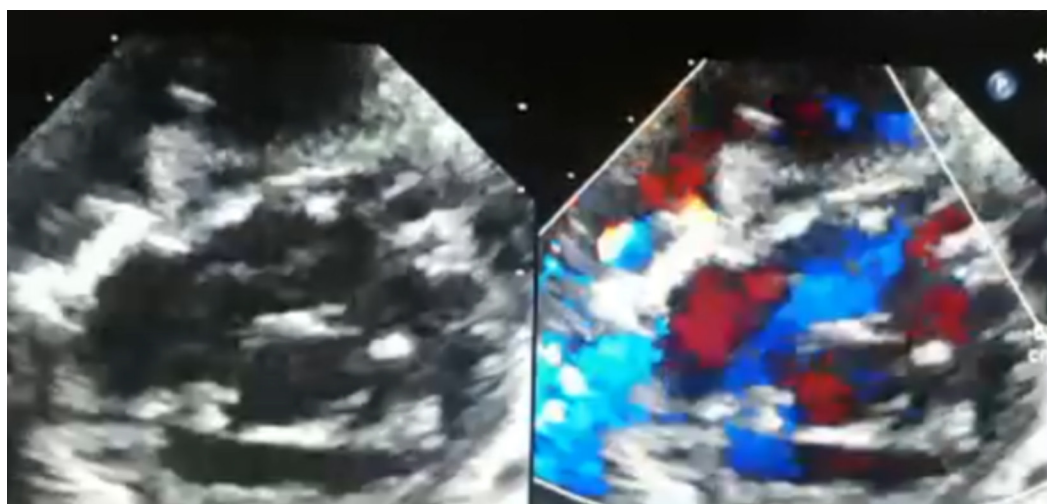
Preoperative echocardiogram showing tricuspid valve with 33% attachment of the septal leaflet to the interventricular septum.
